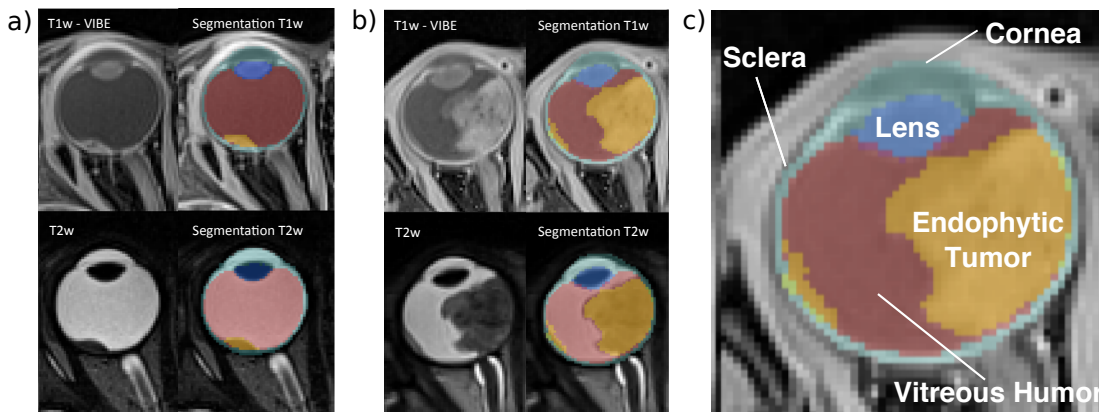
Patients with retinoblastoma (a)-(b) Two example patients imaged with 3D T1w VIBE & T2w MRI (c) The eye lens (dark blue), vitreous humor (red) and sclera / cornea (light blue) are highlighted. Endophytic tumors delineated in yellow.
